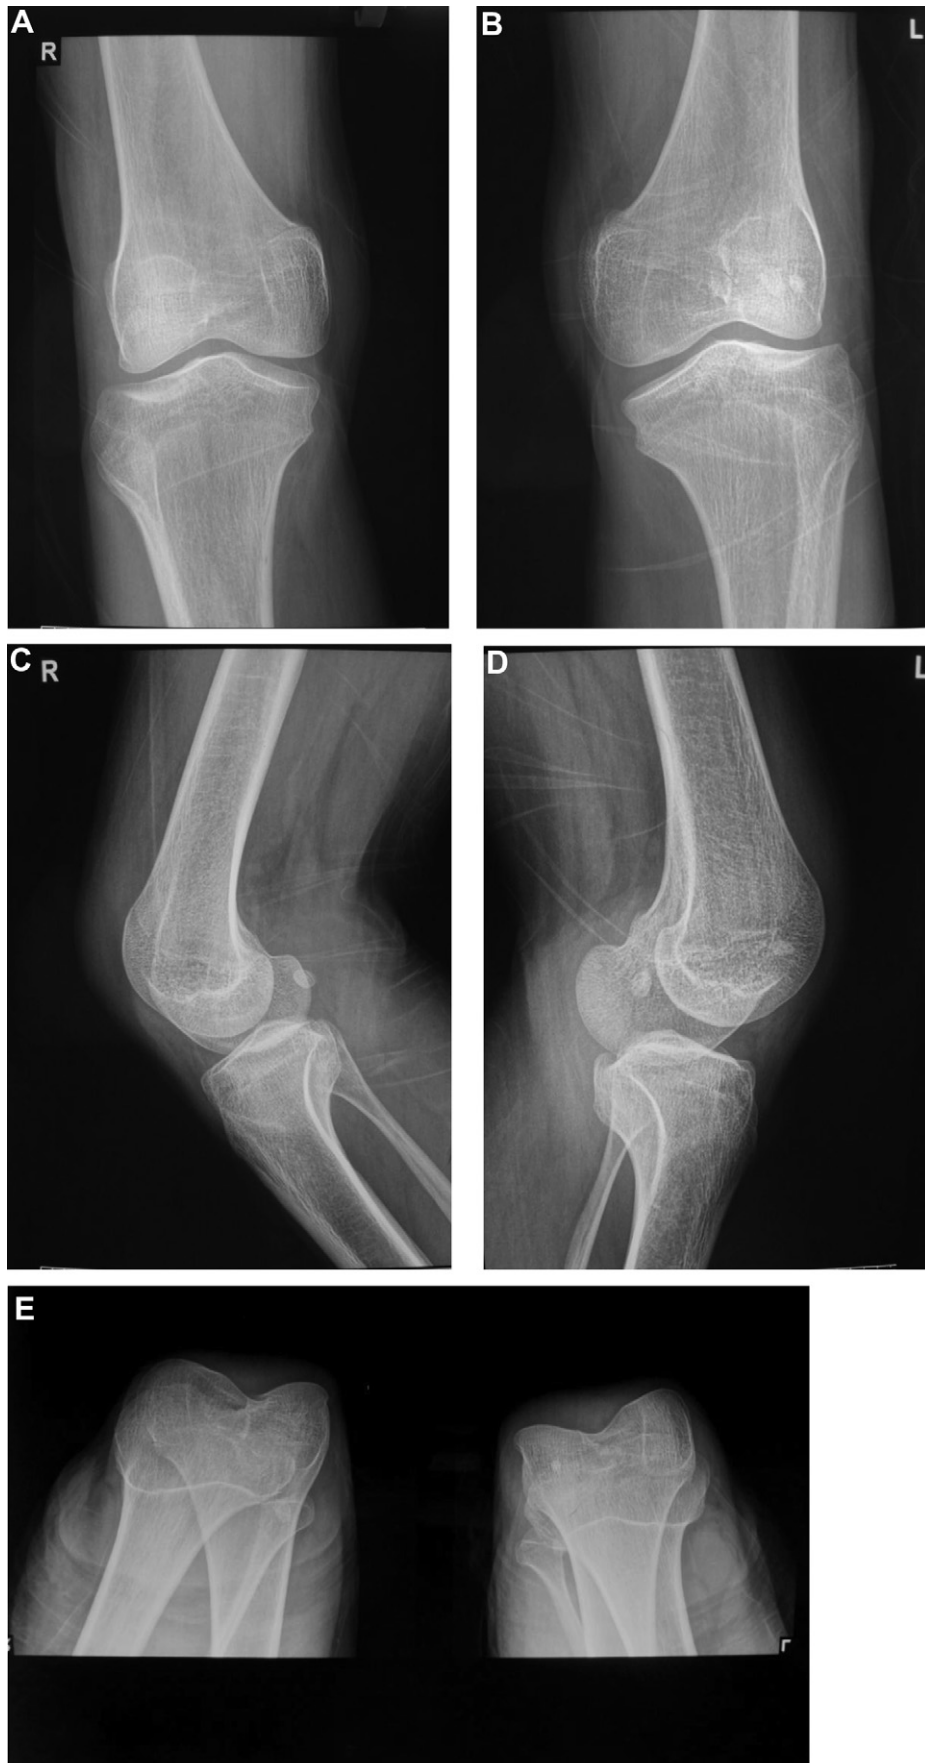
Anteroposterior (A,B), lateral (C,D) and tunnel (E) radiographs of bilateral absence of the patella.
